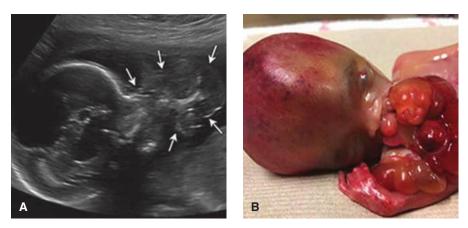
Epignathus, ultrasound (A) and postdelivery (B) images. This teratoma arises from the oral cavity or pharynx and may grow outward from the mouth or both outward and into the brain, as in this fetus (*arrowhead*). Arrows depict the external extent of the mass. (Reproduced with permission from Halima Abdirahman, RDMS.)
